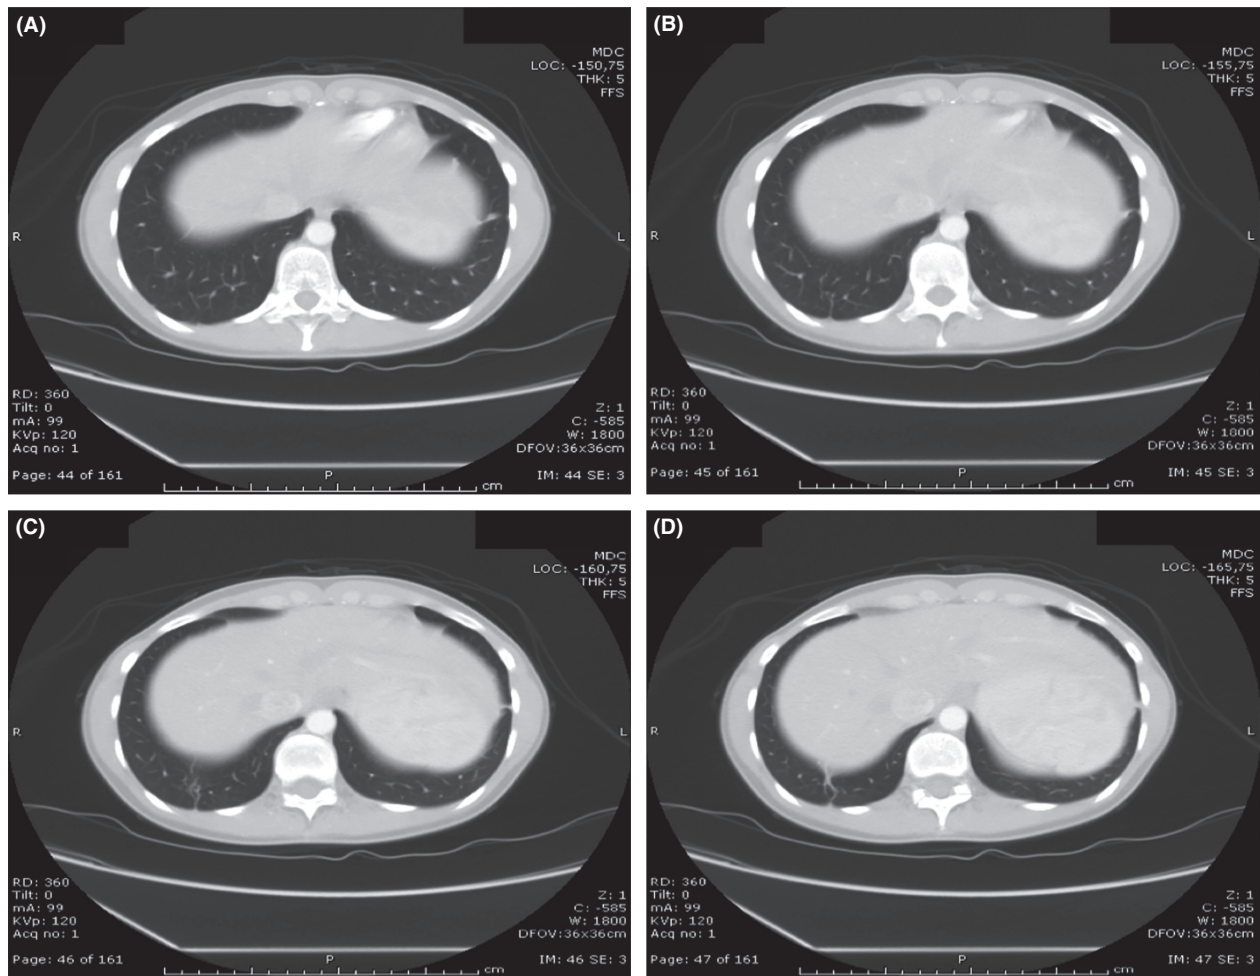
HRCT scan made 12 months later with complete resolution of the pulmonary lesion.
